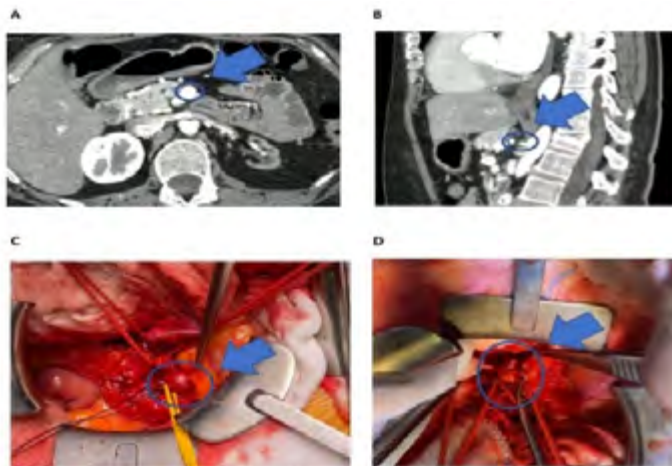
A) B) CTA showing inferior pancreaticoduodenal saccular aneurysm and stenosis of celiac artery (MAL syndrome). C) Aneurysm of the anterior pancreaticoduodenal artery with proximal and distal control (red and yellow silastic slings); D) resection of the PDAA with reimplantation of pancreaticoduodenal artery in superior mesenteric artery
